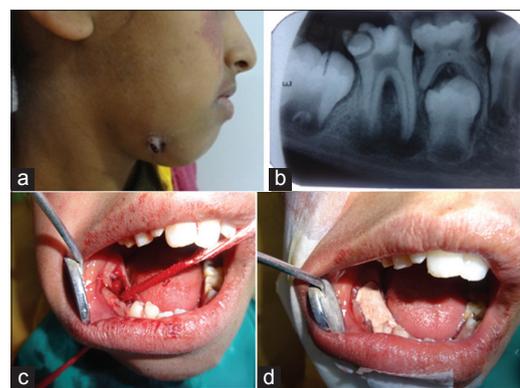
(a) Pre-operative - extraoral sinus, (b) IOPA showing big periapical radiolucency w.r.t 46, (c) cleaning the sinus tract with gauze soaked in povidone-iodine, (d) Coe-pack placed for healing.
